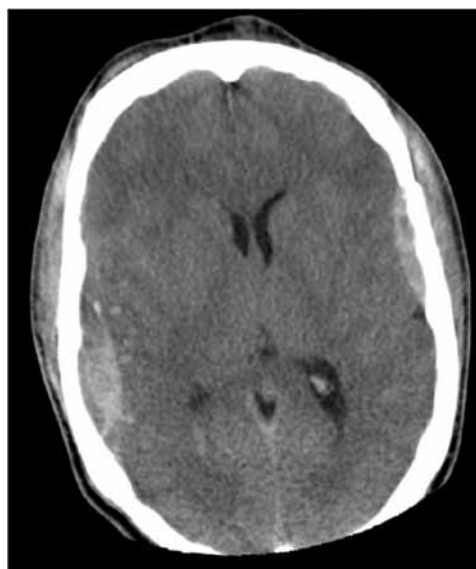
CT head scan of patient 2
